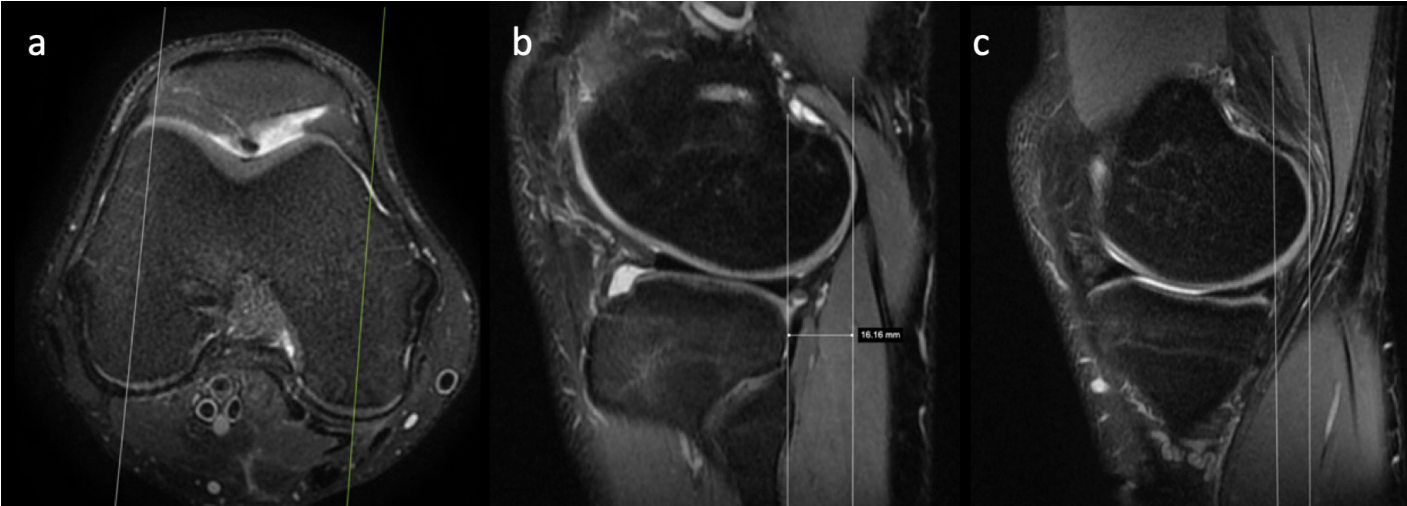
MRI-based ATT measurement technique; (a) Axial image used to identify the femoral condylar level; (b, c) Sagittal images demonstrating lateral and medial ATT measurements
